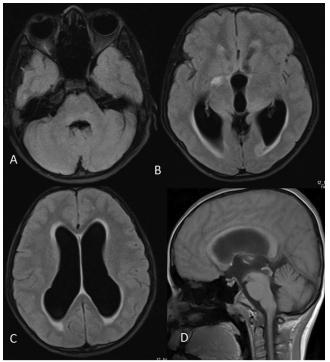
MRI brain (Axial FLAIR: A-C, Sagittal T1- D) showing normal sized fourth ventricle(A), dilated third (B) and both lateral ventricles(C) and dilated superior portion of aqueduct due to web in inferior portion of aqueduct (D).
